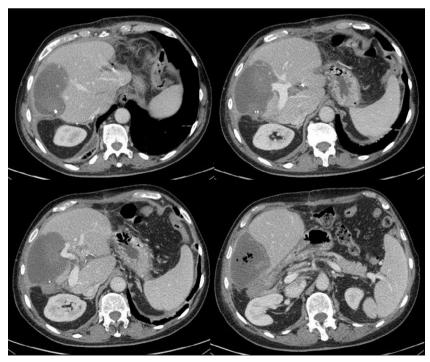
Postoperative CT scan showing necrosis of the parenchyma of segment IV and lack of contrast in portal branches of this segment.
